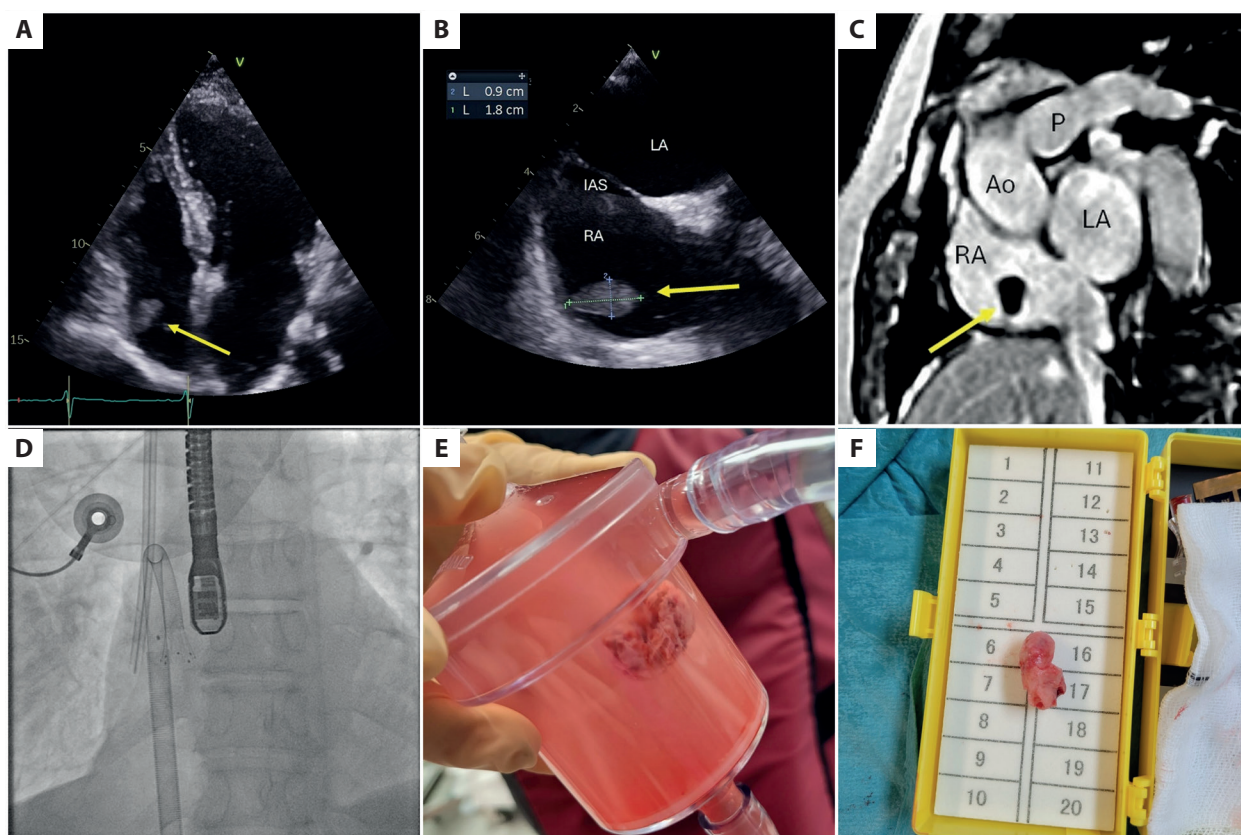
Right atrial mass (arrows) visualized in: A. Transthoracic echocardiogram four-chamber view, and B. Transesophageal echocardiogram mid-esophageal view. C. Thrombus in right atrium: homogeneously low signal intensity mass on early gadolinium enhancement sequence with long inversion time. D. Fluoroscopy image anterior-posterior view, AngioVac system introduced into right atrium. E. Fibrotic thrombus in filter chamber. F. Removed clot with measured length of 20 mm
